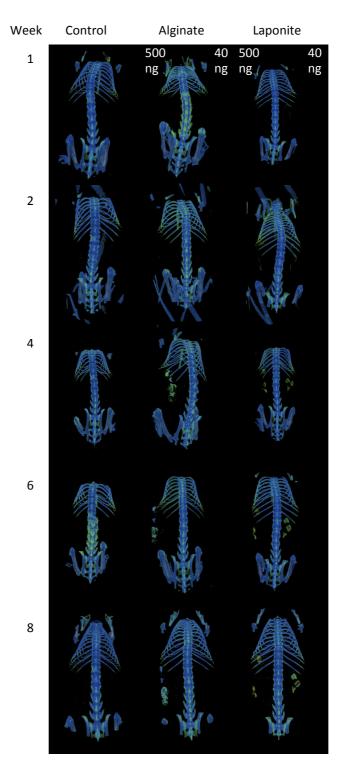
μ CT enabled longitudinal analysis of ectopic bone formation at week 1, 2, 4, 6 and 8. Alginate and Laponite gels loaded with 500 or 40ng doses of BMP2 were perfused through a collagen sponge scaffold and implanted subcutaneously. 500 ng loaded gels were implanted in the left, 40 ng loaded gels were implanted in the right hand sub-cut region. Controls consisted of collagen scaffold alone.
